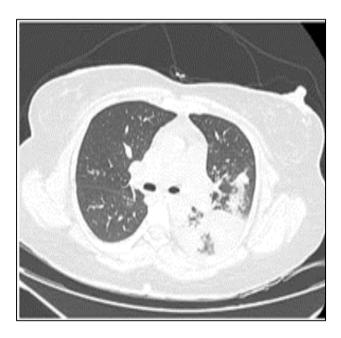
CT chest showing left lower lobe consolidation.
